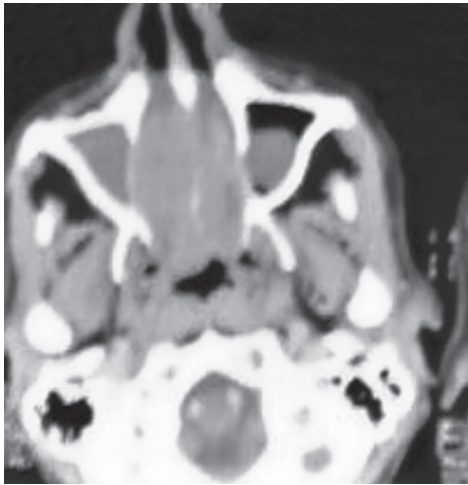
CT scan of a patient with adenoid cystic carcinoma. Tumor was seen filling the bilateral nasal cavity with erosion of septum. During surgery, the tumor was seen arising from posterior end of nasal septum and extending into bilateral nasal cavity
